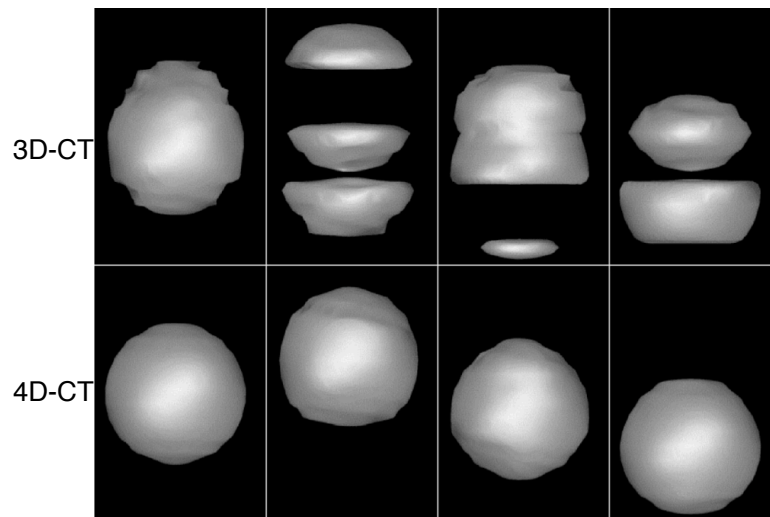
Iso-surface renderings of a spherical object scanned by 3D-CT (top) and 4D-CT (bottom) at different positions of the motion cycle. Three dimensional CT showed a severe motion artifact, and the artifact changed at different positions of the motion cycle [68]. (Permission to reproduce has been granted by the American Association of Physicists in Medicine.)
